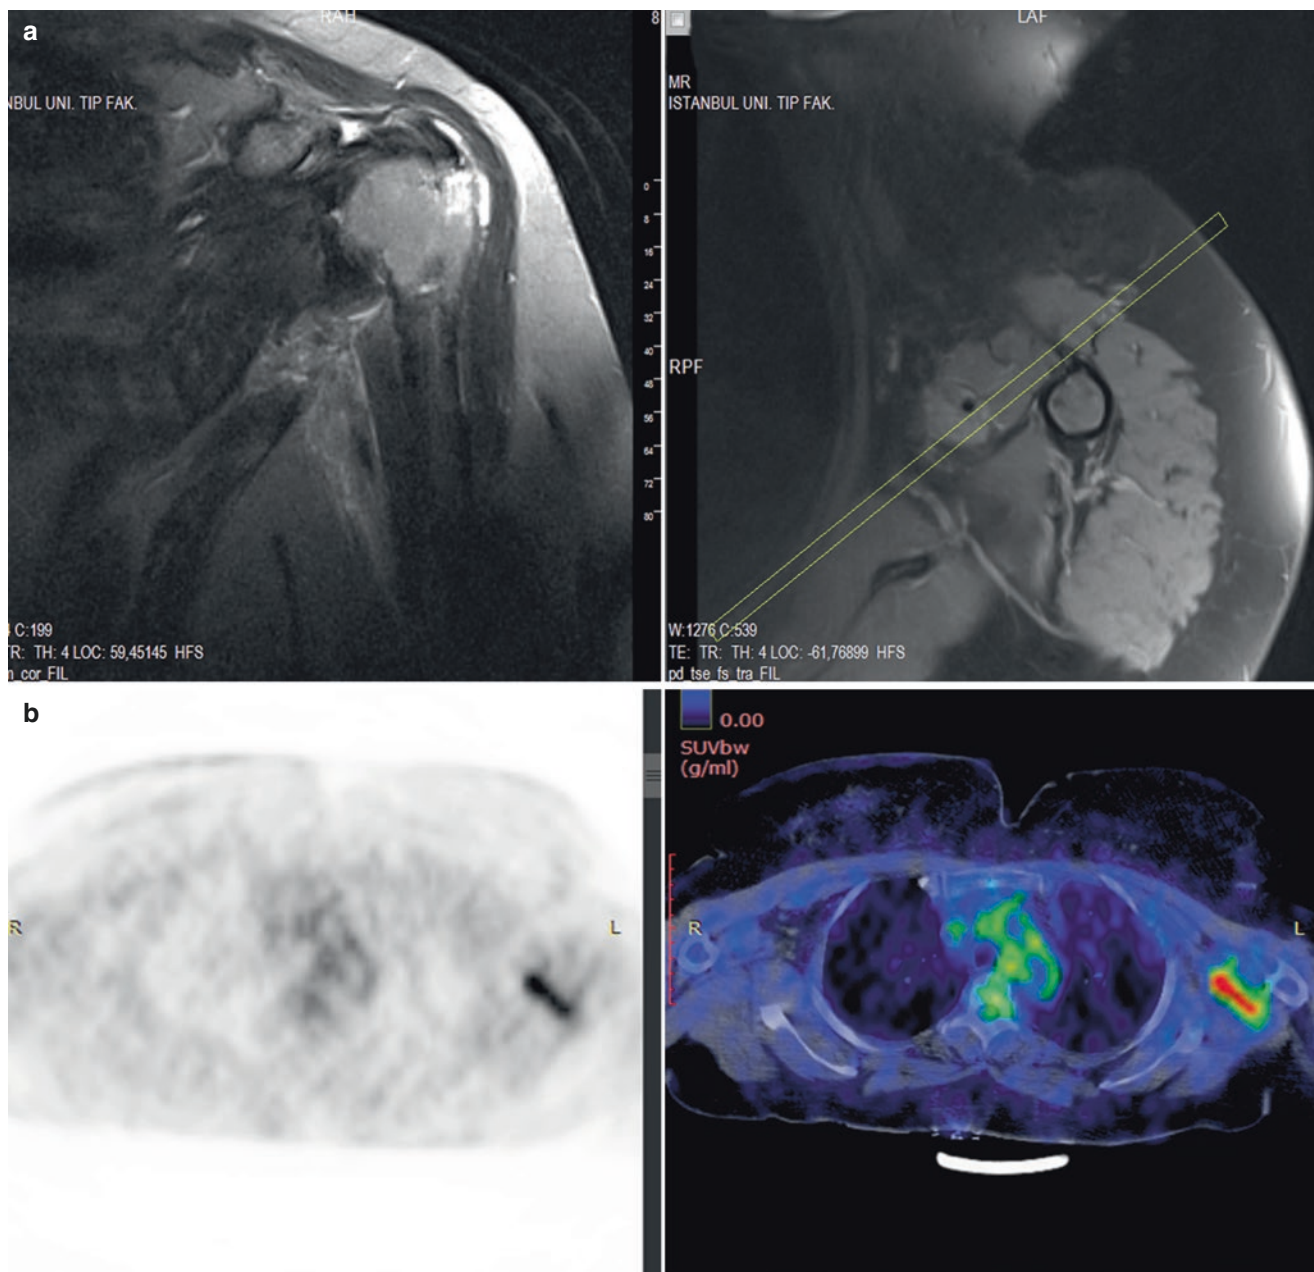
(a) Coronal and axial view of brachial plexopathy in MRI. (b) Axial view of brachial plexopathy in PETCT. (c) Coronal view of brachial plexopathy in PET-CT
